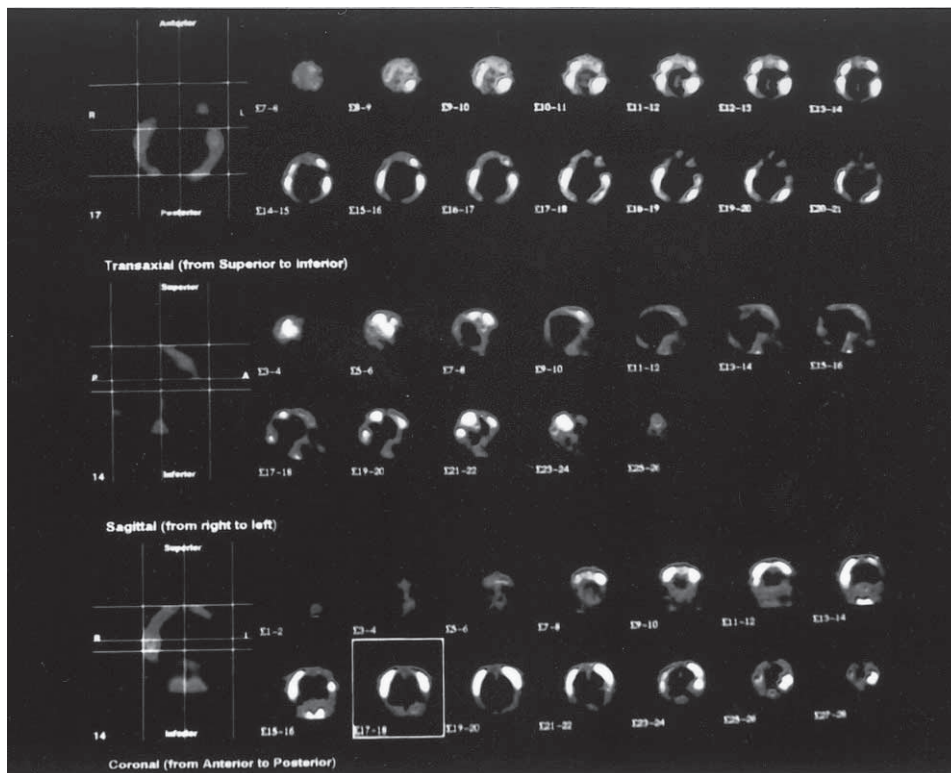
Cross sections of transaxial, sagittal, and coronal images of the brain were obtained during the SPECT study with Tc-99m nanocolloid. There was increased radiotracer uptake in bilateral parietal, bilateral frontal and left occipital bones and especially in falx cerebri of sinus sagittalis superior.
